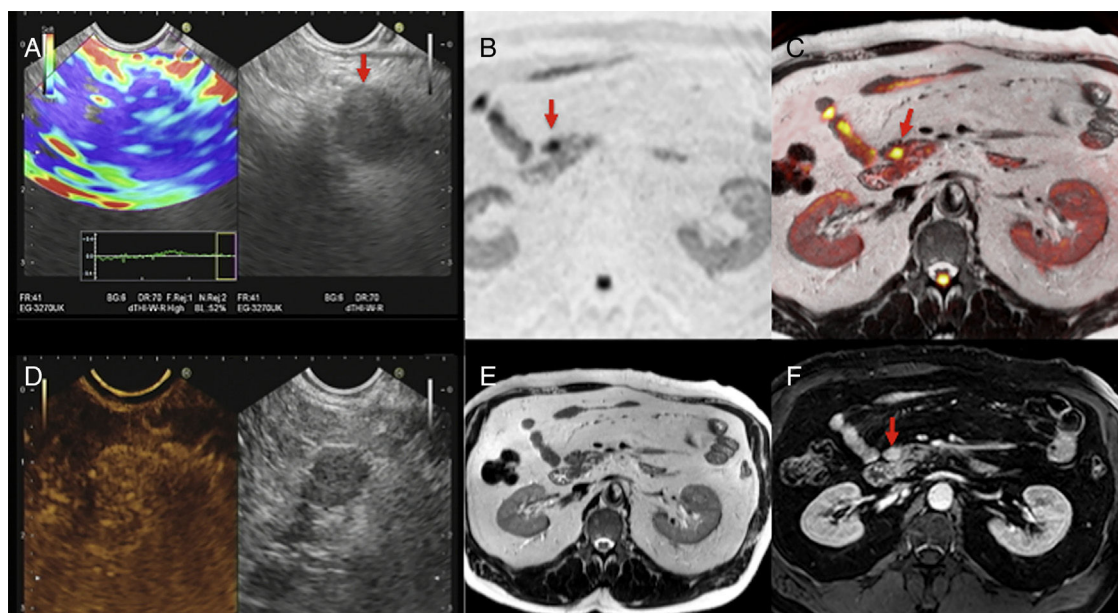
Multimodal image of one pancreatic neuroendocrine tumor. Images of an endoscopic ultrasound with elastography (A), diffusion imaging in $b1000$ with gray-scale inversion (B), fusion of the T2-weighted imaging and the diffusion imaging in $b1000$ in color (C), endoscopic study with ultrasound contrast (D), T2-weighted MRI (E) and T1-weighted MRI with contrast in the portal phase (F). The endoscopic ultrasound scan shows one lesion (red arrow in A) with a homogeneous blue elastographic pattern (common of malignant tumors) and enhancement after the administration of contrast (D). The MRI with diffusion (B) and the fusion imaging color map (T2 + diffusion) (C) clearly show one small tumor in the pancreatic isthmus that looks more enhanced than the parenchyma after the administration of paramagnetic contrast (F) (red arrows).
